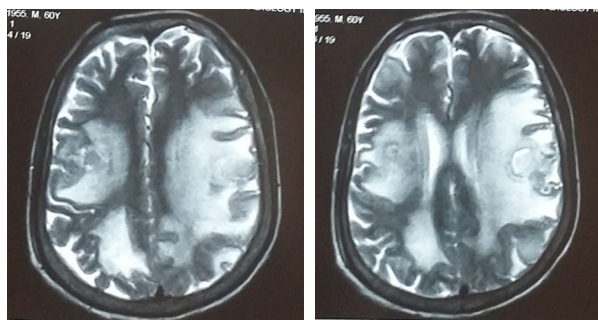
T2 weighted MR images of the brain at the level of lateral ventricles show multiple high signal intensity lesions with isointense thin wall in both frontal and left parietal lobes. Marked hyperintensity in surrounding brain parenchyma, predominantly in white matter represents perilesional edema.
